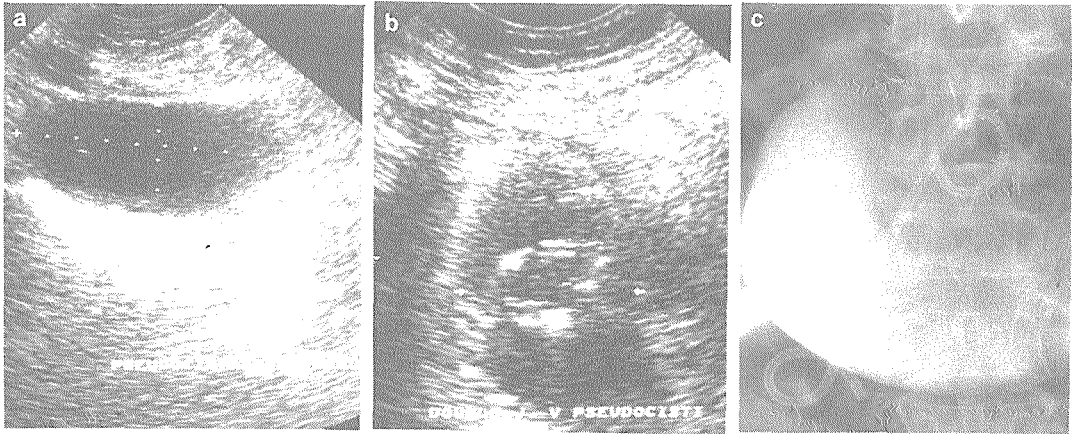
(a) US shows smaller pseudocyst diameter after percutaneous drainage and (b) final position of the drainage catheter seen on US, and (c) Xray.
